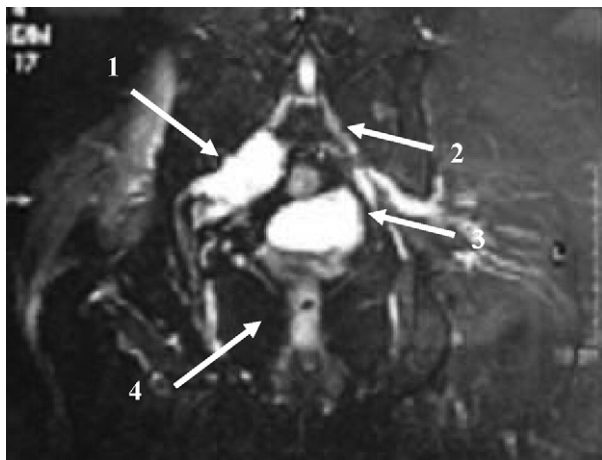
Right posterior fat sat-T2 weighted coronal MRI shows multilocular biseptated lesion along the sciatic nerve. (1) Multilocular, septated cystic hydatid; (2) sacral vertebrae; (3) rectum; (4) pelvic muscles.
